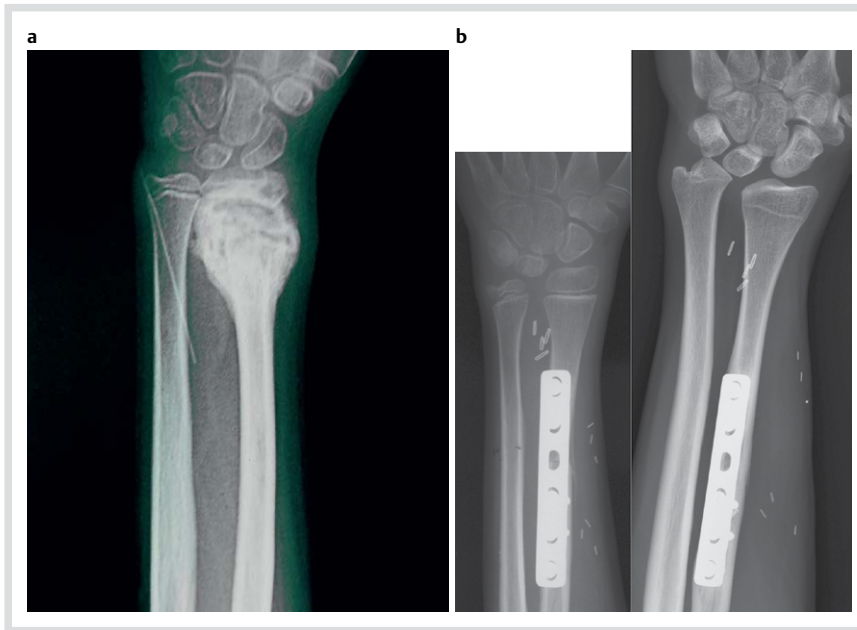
a Preoperative X-ray; b In our series the fibular growth after the transplant ranges between 0.7 and 1.4 cm per year depending on several factors.
